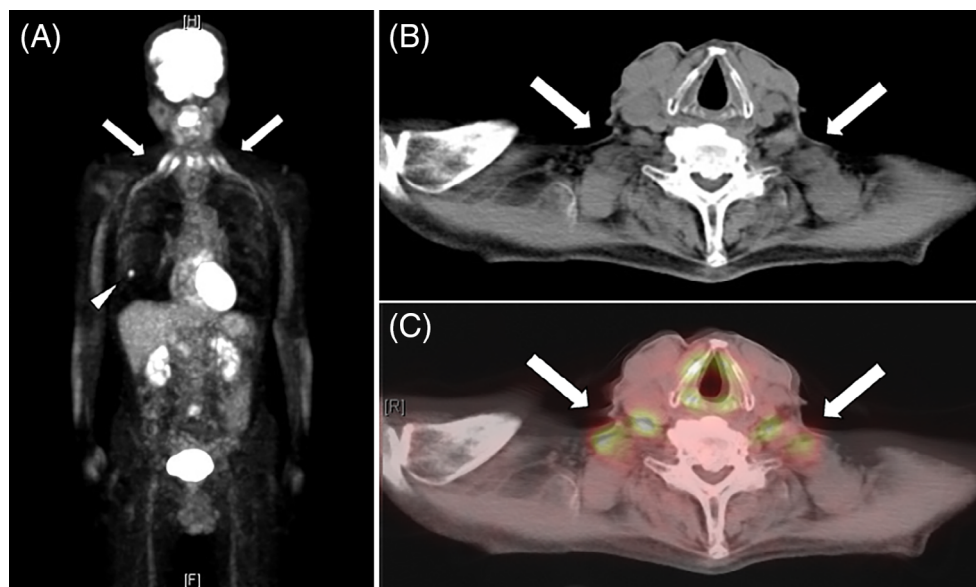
(A) A positron emission tomography image shows bilateral uptake in both supraclavicular regions (white arrows), in addition to the right lower lobe nodule (white arrowhead). (B) A corresponding computed tomography image (B) and fusion image (C) show uptake in both scalene muscles (white arrows)
